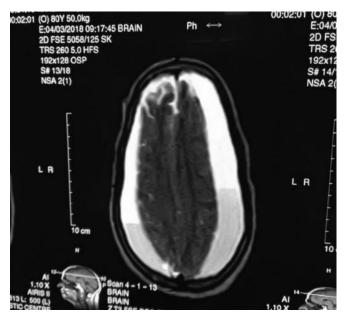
MRI of Bilateral Chronic Subdural Hematoma.
